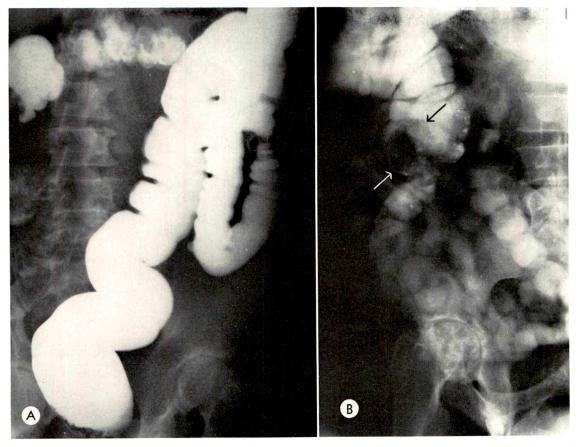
Case No. A5327. Fifty-one year old white male with chief complaints of gastrointestinal bleeding and anemia. (A) Barium enema study shows barium from the rectum to the proximal transverse colon with complete blockage. There is an irregular contour suggesting the distal border of a tumor. The examination was supplemented by orally administered hypaque 40 per cent. (B) At 4 hours the proximal colon is well visualized. A well defined fungating more or less polypoid lesion is demonstrated, which is approximately 5 cm. in diameter, in the mid-ascending colon. The roentgenologic diagnosis of polypoid tumor—adenocarcinoma of the ascending colon—was confirmed at operation.
